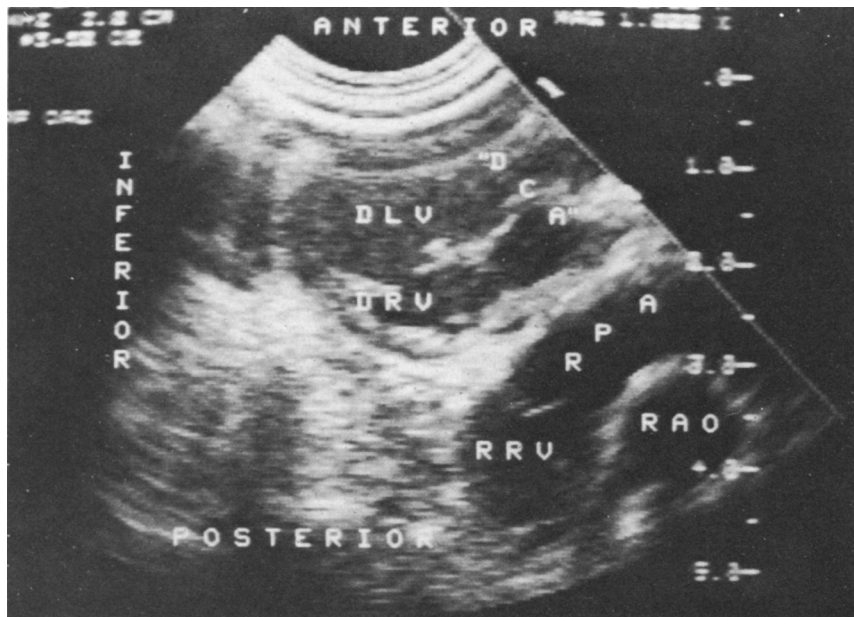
Two-dimensional Doppler echocardiogram of neonatal heterotopic heart transplant. This view is obtained through the lateral left chest wall with the donor heart closest to the transducer. *DCA*, Donor coronary artery. For other abbreviations see Fig. 1.
